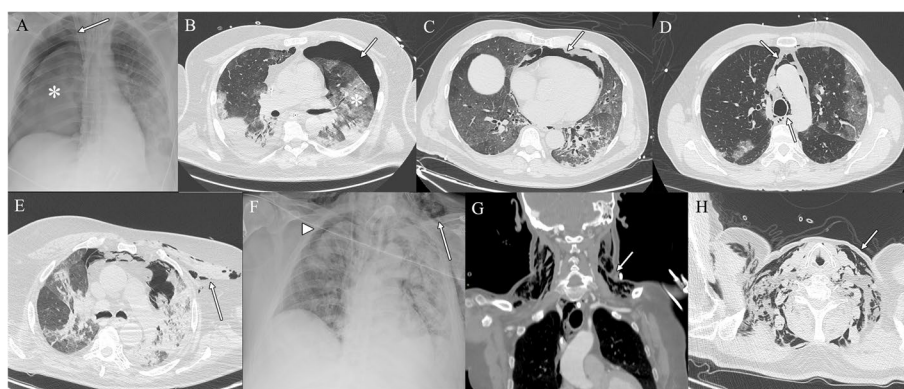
Plain X-ray chest of a critically ill COVID-19 patient admitted to the ICU demonstrating the presence of radiolucent air in the pleural space (arrow in A) and the partial collapse of the right lung (asterisk in A), causing a mediastinal shift. Axial HRCT images of severely ill patients infected with the SARS-CoV-2 virus showing imaging features suggestive of barotrauma: a large pneumothorax (arrow in B) with collapsed left lung (asterisk in B), a large pneumopericardium (arrow in C), a pneumomediastinum with air collecting around the trachea and the main mediastinal vessels (arrows in D), pneumothorax and pneumomediastinum associated with extensive left subcutaneous emphysema (arrow in E). Plain X-ray chest of a critically ill COVID-19 patient demonstrating the presence of both a right pneumothorax (arrowhead in F) and free air entering the neck (arrow in F); coronal and axial CT images of the same patients, showing the presence of free air dissecting within the fascia spaces of the neck (arrows in G and H)
